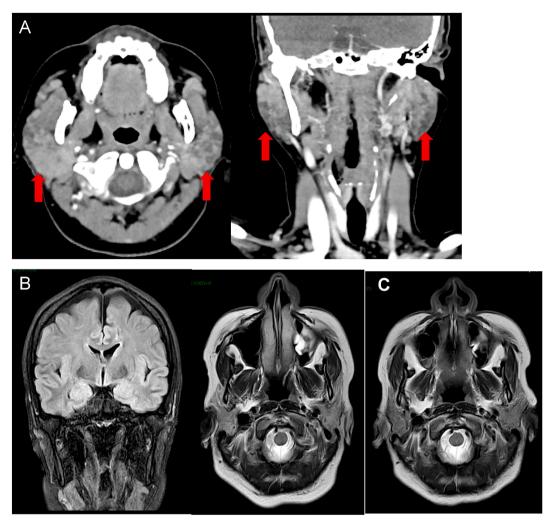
(A) October 3, 2019 CT Parotid: Bilateral enlarged parotid glands with inhomogeneous nodular enhancement (arrow). There was mild left maxillary sinusitis. (B) March 23, 2019 MR Head: Normal parotids (coronal FLAIR); MR (axial T2). (C) May 6, 2020 MR Head: Normal parotids.
